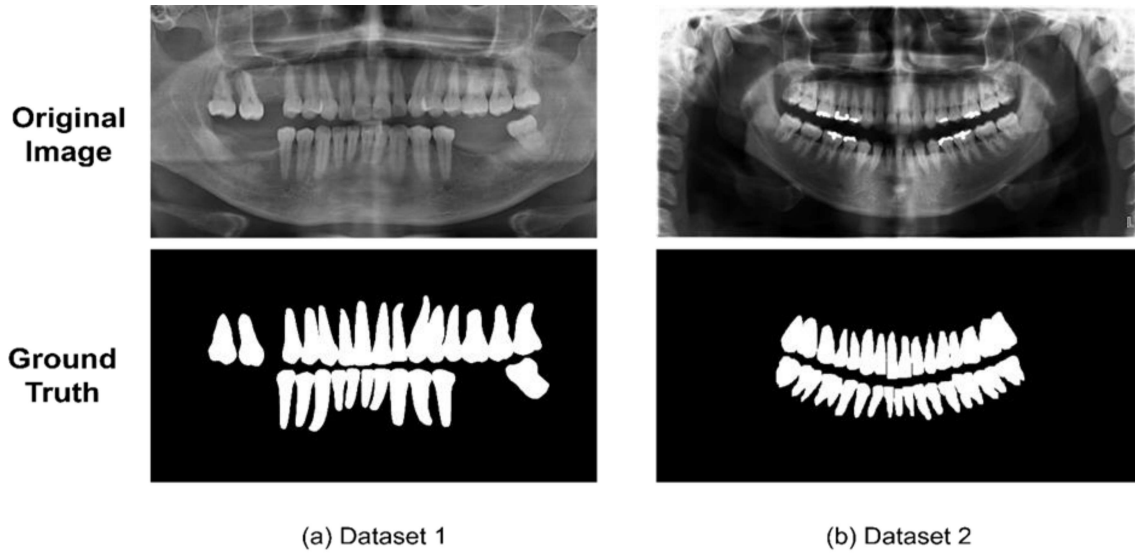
Sample from Datasets of dental panoramic X-ray images
